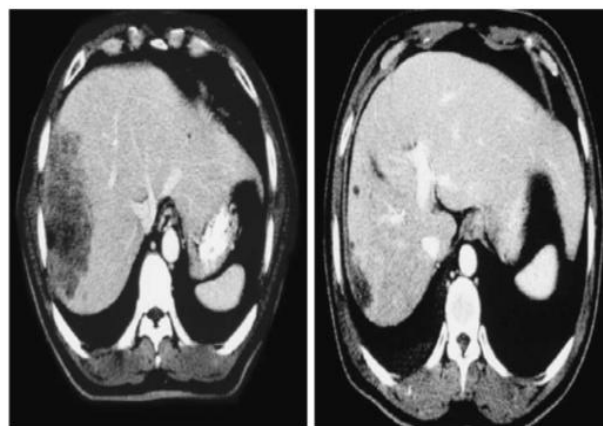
Radiographic response of hepatocellular carcinoma after radiation. The left image is a CT scan taken before radiation therapy; while the right one is 6 months after the completion of radiation therapy (Courtesy of Dr. Theodore Lawrence) [2]
